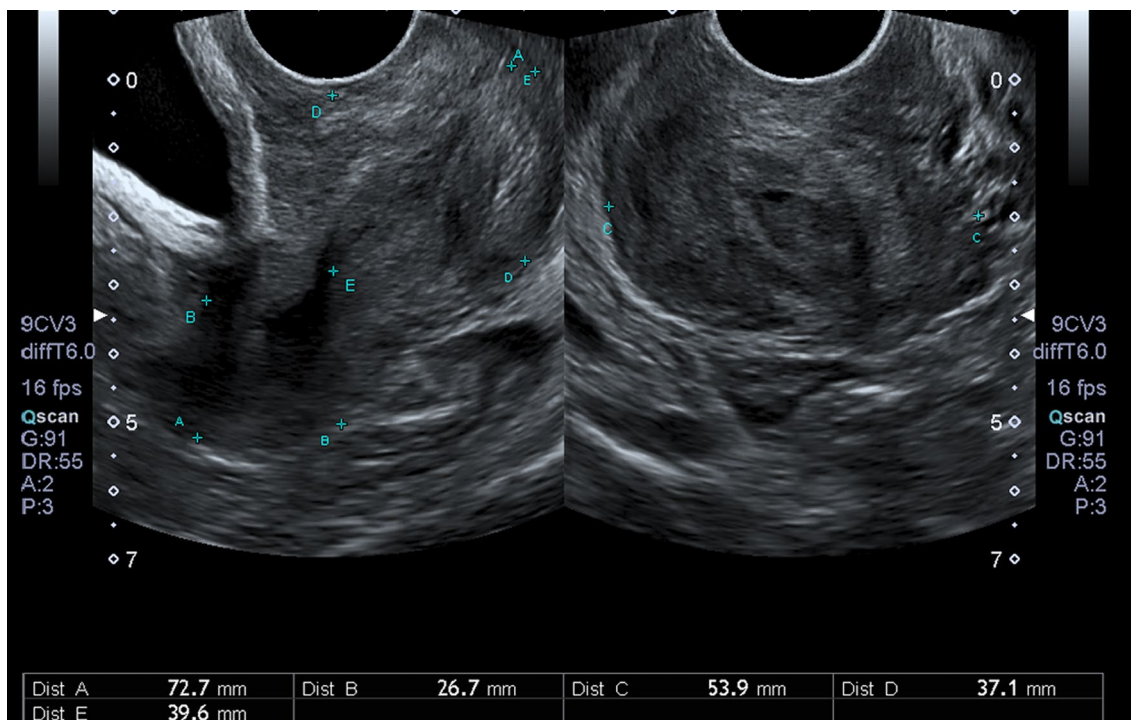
On day 2 after admission, endovaginal ultrasound revealed an enlarged cervix measuring 53.9 × 37.1 × 39.6 mm
